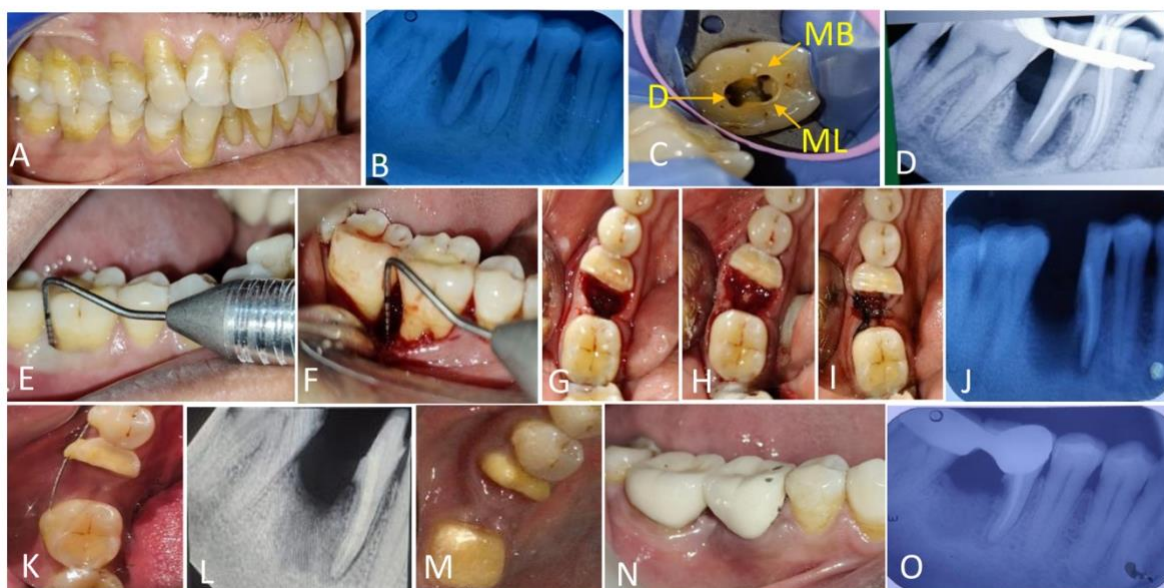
Case 2. (A) Fair oral hygiene status. (B) Radiograph showing a vertical radiolucency around the distal root of tooth #46. (C) Intraoperative view showing the mesiobuccal, mesiolingual, and distal canals. (D) Master cone radiograph confirming working length. (E)
